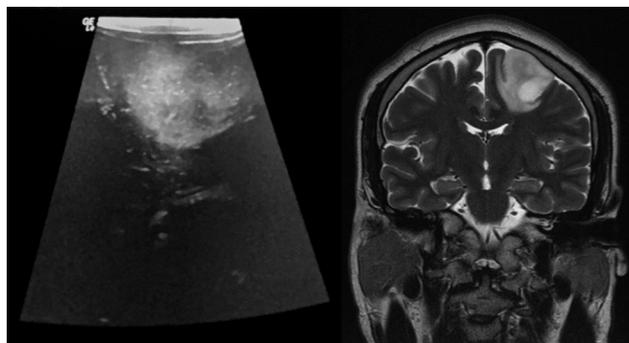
Intraoperative US image of a frontal low-grade glioma; note its hyperchoic compared with the healthy surrounding tissue. When compared with the preoperative MRI, it shows adequate anatomical similarity. To obtain this image, the transducer is placed perpendicular to the midline giving a coronal view. MRI, magnetic resonance imaging; US, ultrasound.
